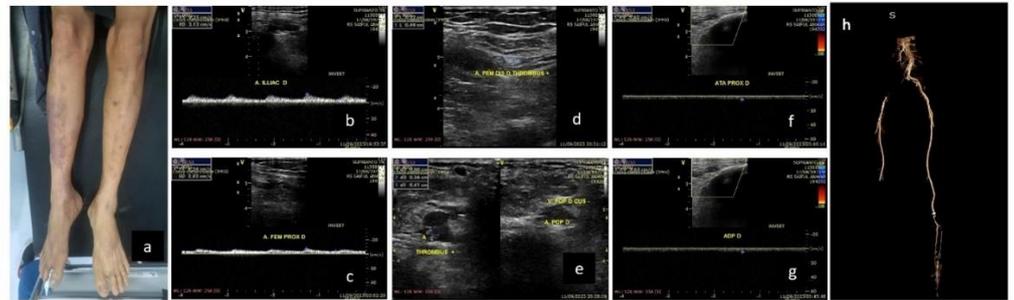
Diagnostic imaging and clinical presentation of acute limb ischemia. (a) Clinical picture showing bluish right lower leg. (b, c) Monophasic spectral Doppler from right iliac artery to right distal femoral artery. (d) Thrombus at right distal femoral artery. (e) Thrombus at right popliteal artery. (f, g) No flow at distal artery. (h) CT angiography showed total occlusion of the right common iliac artery and total occlusion of the right distal femoral artery.
